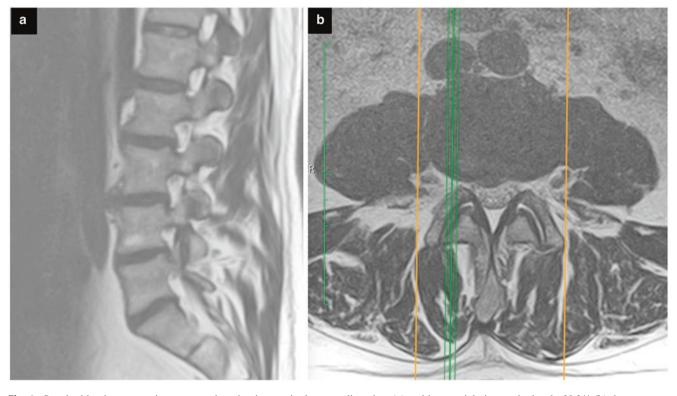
Standard lumbar magnetic resonance imaging in a sagittal paramedian view (\mathbf{a}) and in an axial view at the level of L3/4 (\mathbf{b}) demonstrate anterior disc protrusion close to the vena cava inferior
